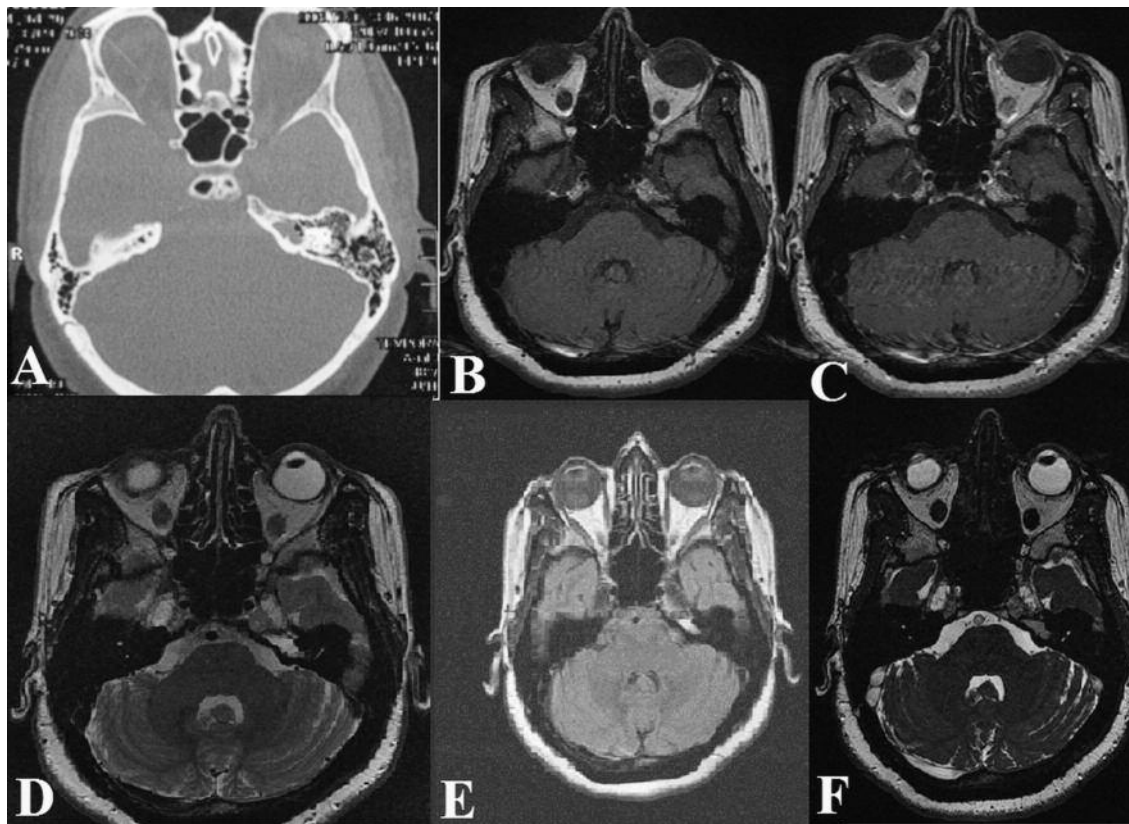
Mucocele in the left PA. A: Axial CT shows smoothly expansile isodense lesion with trabecular destruction; B: T1 WI shows isointense lesion; C: T1 WI with contrast shows an isointense lesion without contrast enhancement; D: Axial T2 WI shows a hyperintense lesion; E: FLAIR shows a hyperintense lesion; F: FIESTA shows hyperintense lesion (hypointense to retroorbital fat tissue).
